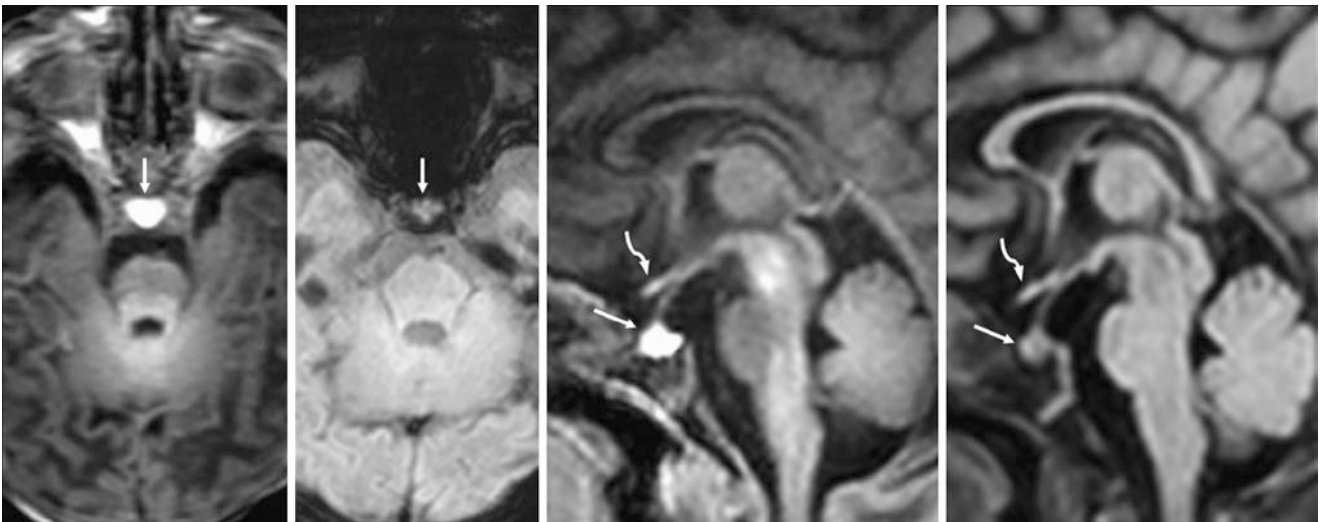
A term 9-day-old had a uniformly hyperintense pituitary gland (*arrows*) on a 3T MRI with a 3D GE T1WI acquisition that was reconstructed in axial (*left*) and sagittal (*right middle*) planes. Note that the bright signal is not related to hemorrhage, as the gland is not dark on SWI (*left middle*). On a sagittal reformat from a 3D FLAIR image (*right*), the gland appears isointense. Note the optic chiasm superiorly (*curved arrows*)
